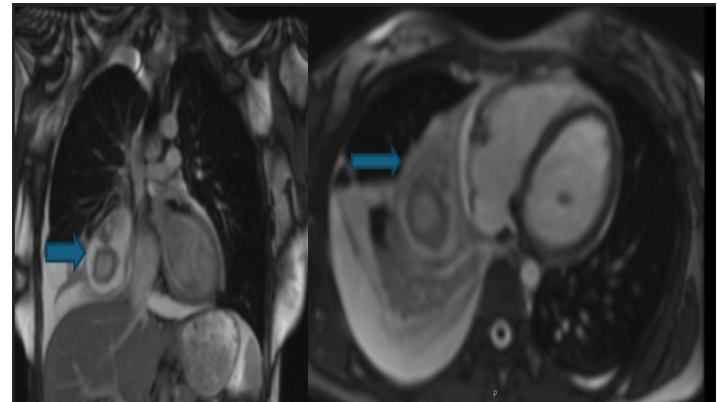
Cardiac MRI (anterior-posterior and axial views) demonstrating a large mediastinal tumor located near the heart and compressing adjacent structures.
